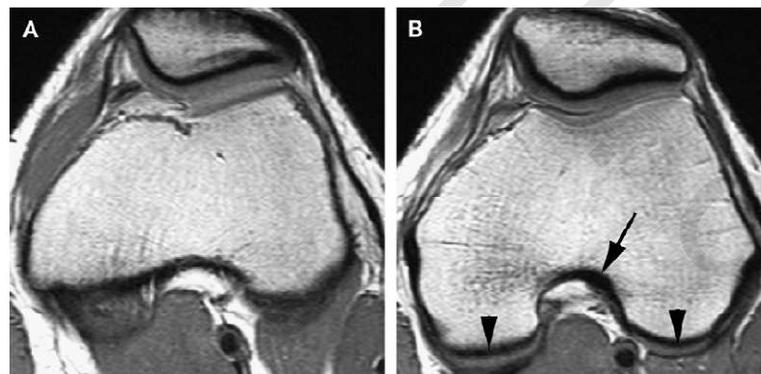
Normal femoral attachment of the ACL on proton density MR imaging.
